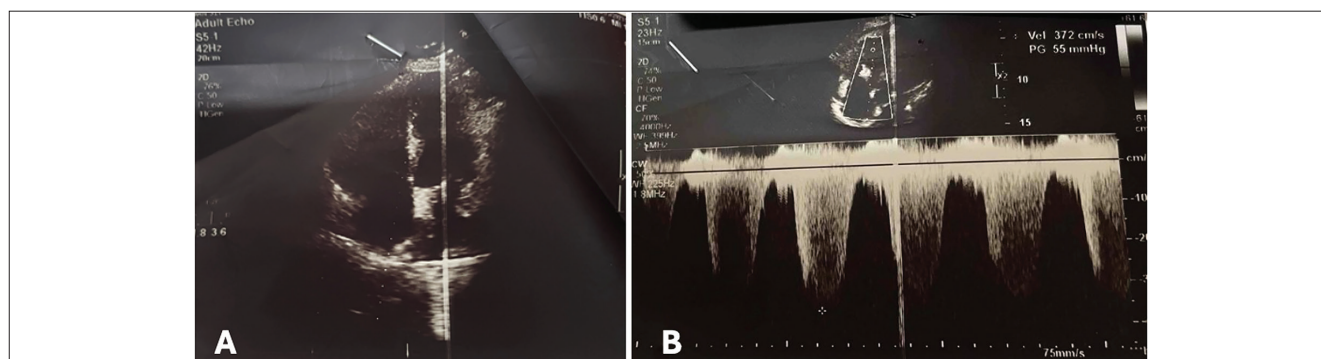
Transthoracic echocardiogram shows right ventricular strain (A) and evidence of pulmonary hypertension with tricuspid regurgitation pressure gradient 55 mmHg (B).
